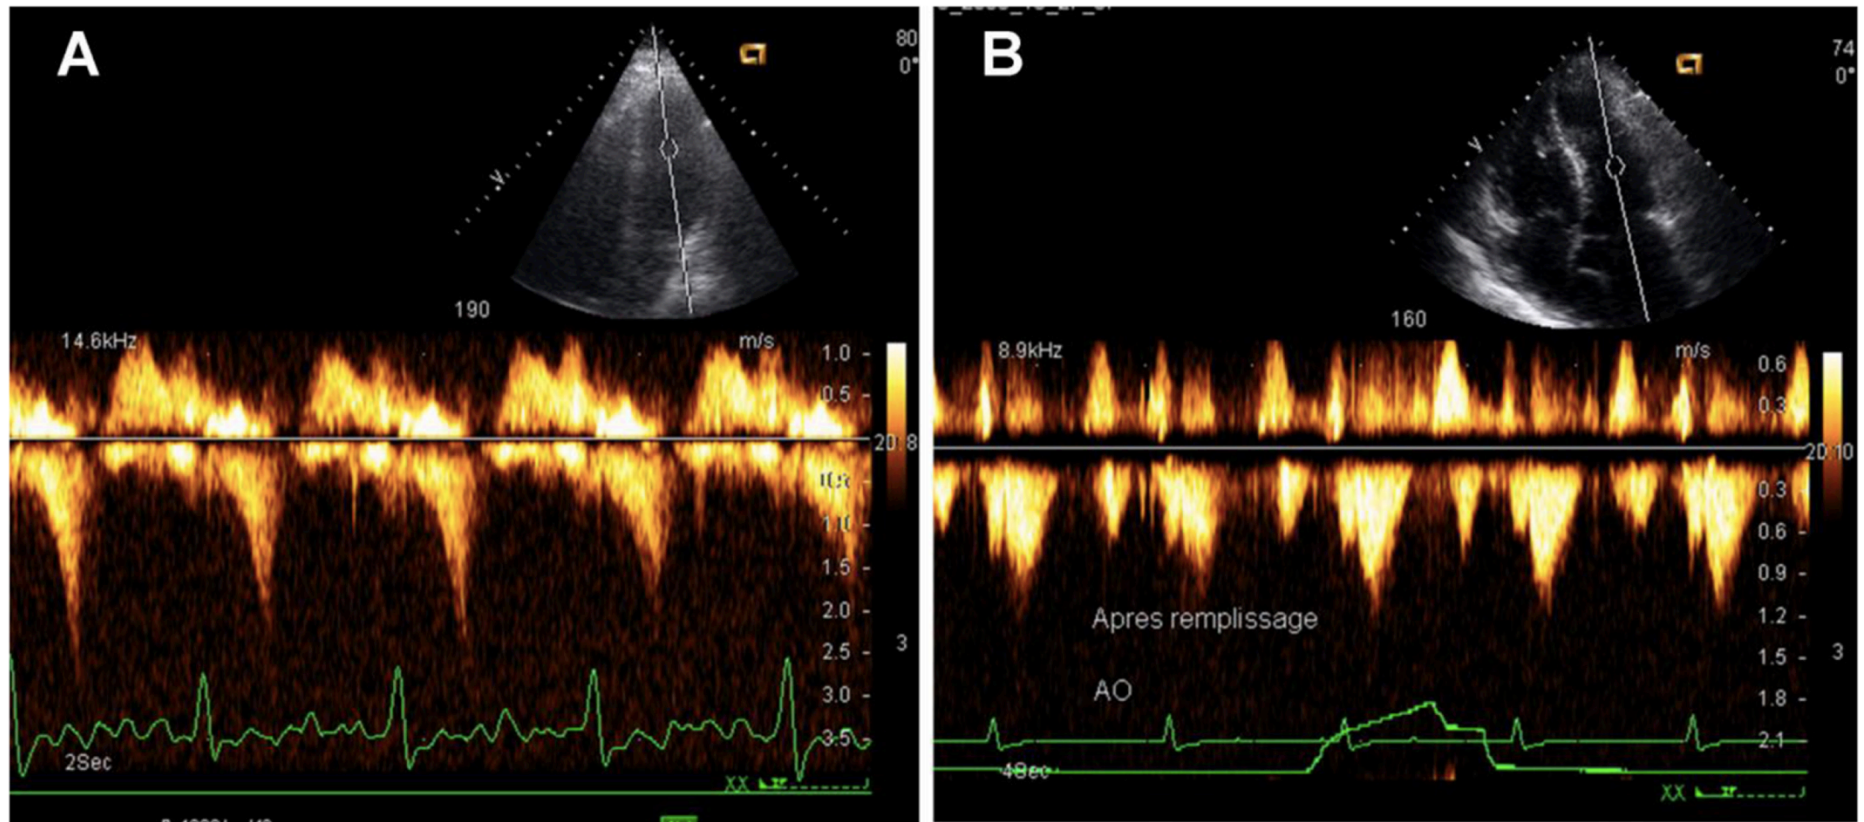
Left intraventricular obstruction. a Pulsed-wave Doppler curve showing the characteristic late peaking saber-shape indicating a LV outflow obstruction (IVG). b After fluid replacement, the flow profile returns to normal symmetrical shape
